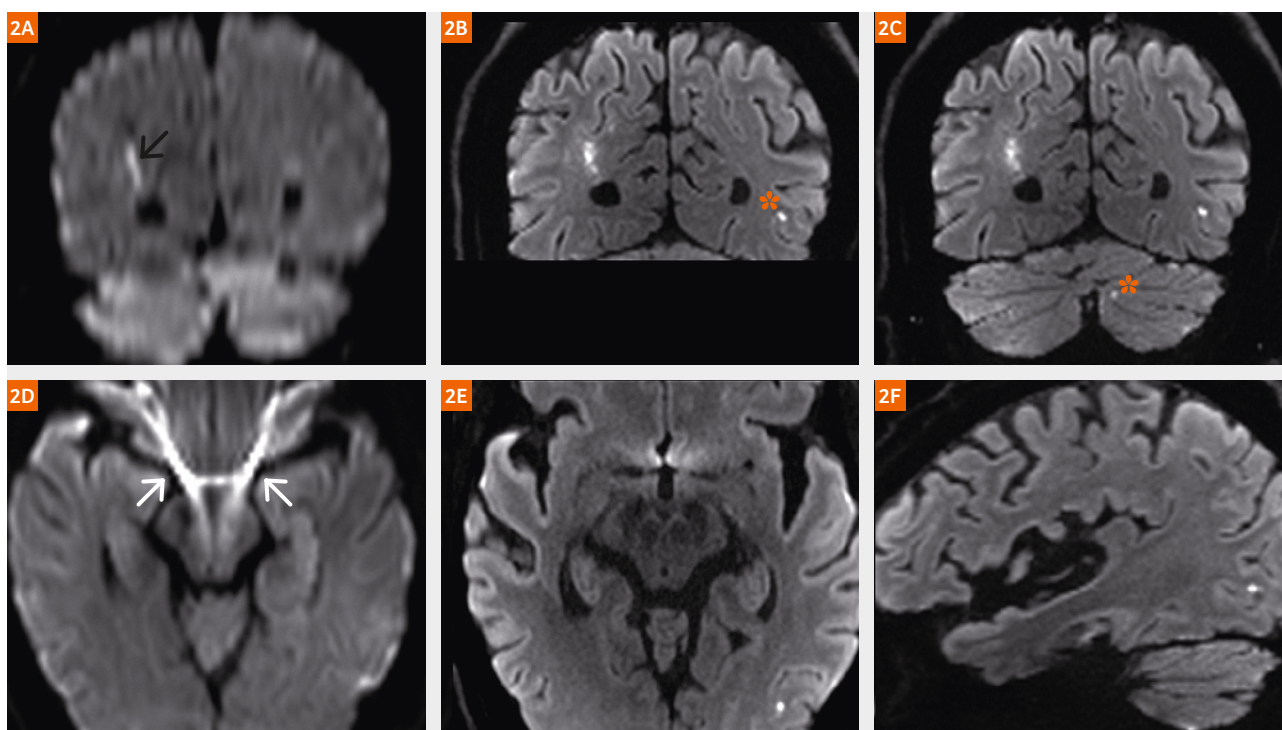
Conventional 2D ss-EPI DWI (2A, D – 5 mm) vs thin section (1 mm), high in plane resolution (0.6 x 0.6 mm²) scans without SMS (2B) and with SMS2 (2C, E, F). At 3T, bulk susceptibility artifacts (white arrows) degrade substantially conventional 5 mm section ss-EPI DWI, as seen in the axial scan (2D). A coronal reformat (2A) in this patient depicts, although poorly due to the low resolution, a small watershed infarct (black arrow). By reducing slice thickness and improving in plane spatial resolution, bulk susceptibility artifacts are reduced and the infarct is well visualized on a reformatted coronal scan (2B, from a 62 image, 1 mm slice thickness, 4:24 min:sec scan). However, the entire brain cannot be scanned
